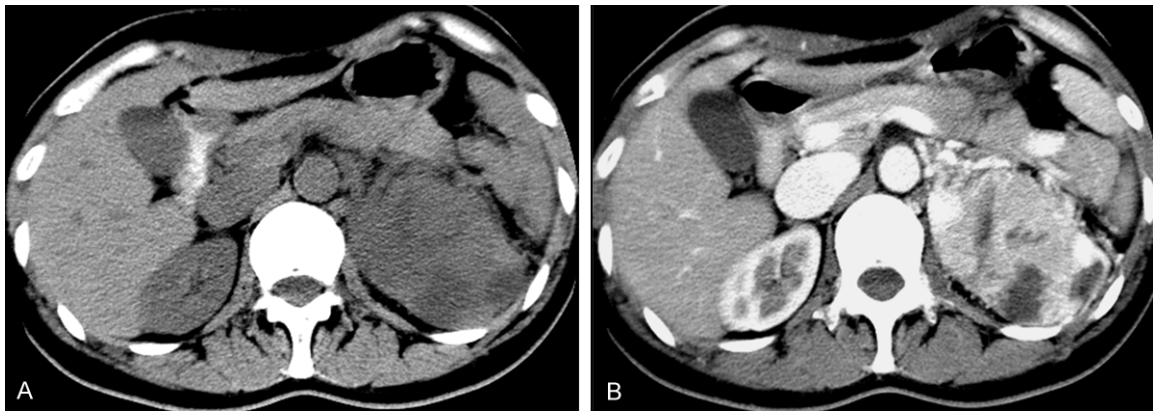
A 68-year-old male with cortisol producing adenoma of the left adrenal gland. A. The mass shows ill-circumscribed, ovoid shape and heterogeneous attenuation on non-enhanced CT. B. The mass presents markedly heterogeneous enhancement after contrast administration.
